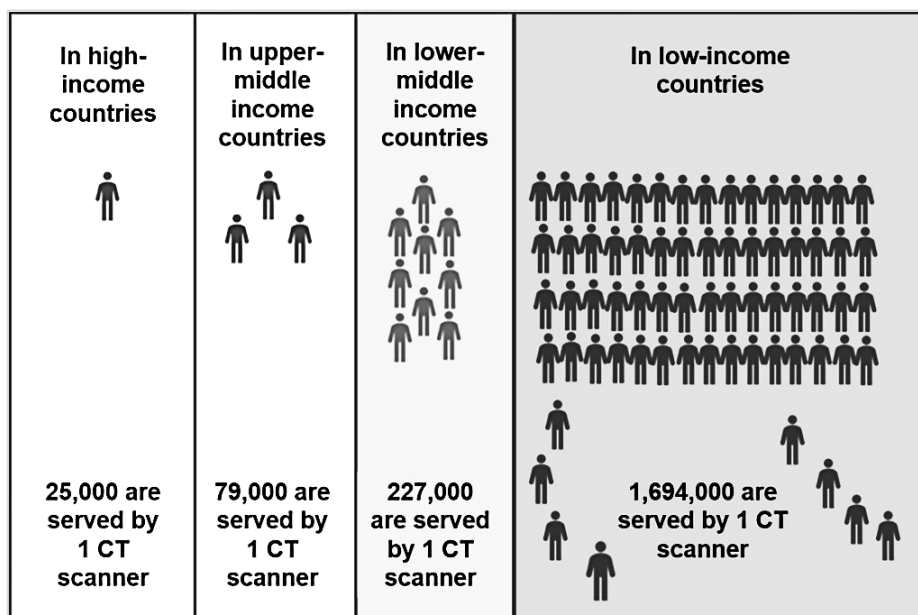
depicts disparities in access to CT scanners around the world. Ireland falls between the upper-middle and high-income countries brackets, while most countries of SSA fall into the low-income countries bracket.
